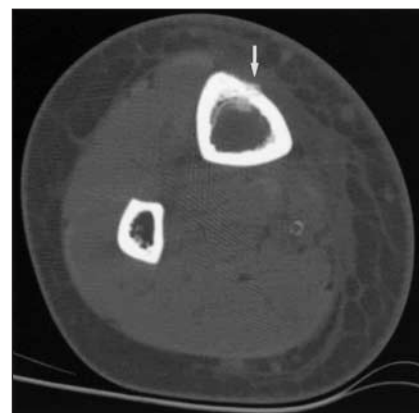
Computed tomographic scan with axial imaging.
